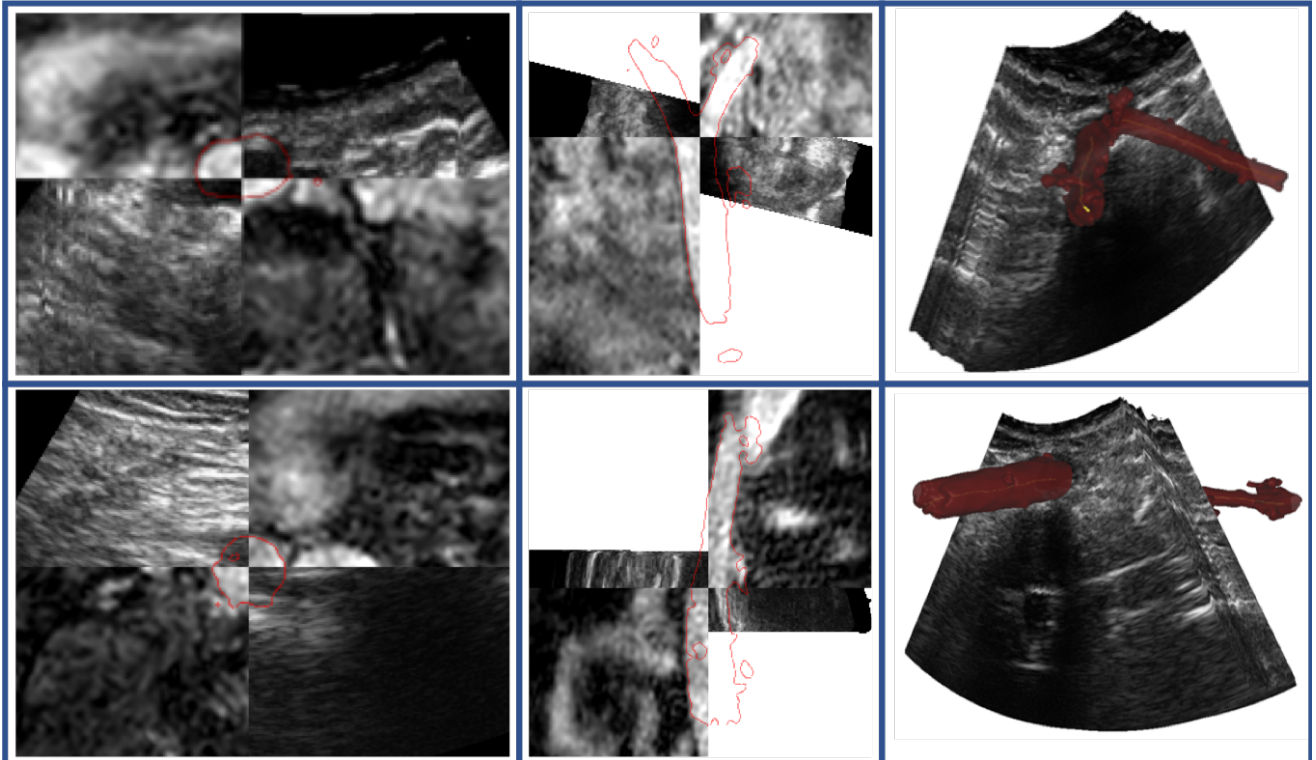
Registration validation on volunteers. US sweep overlapped with MRI (transverse view - left column, coronal view - center column), and 3D view of a validation sweep with the respective vessel segmented from MRI (right column).
